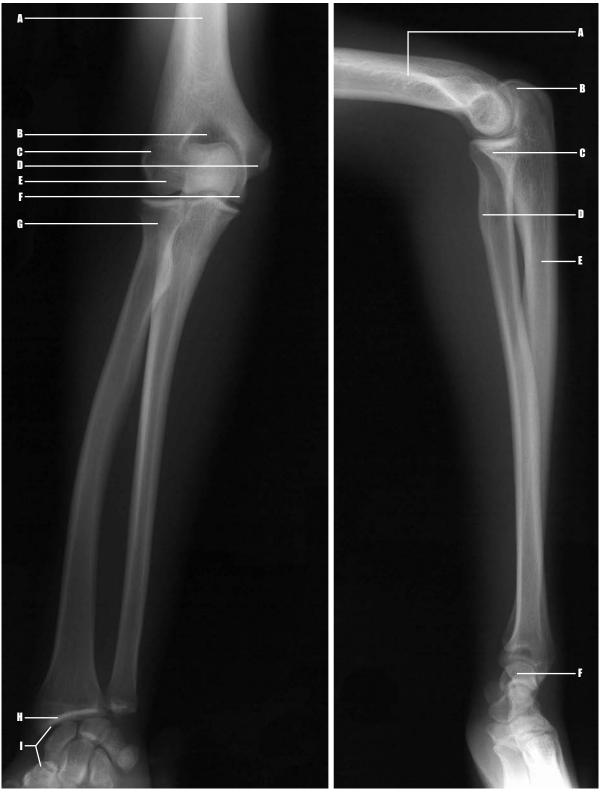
Adult patient, plain film radiograph, anteroposterior view of left forearm.
